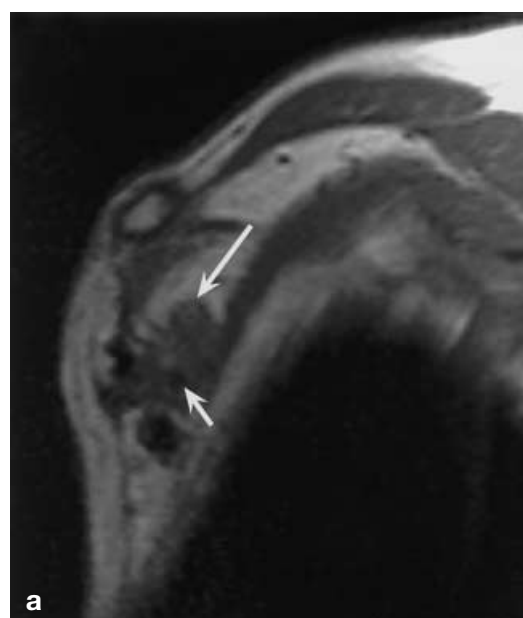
A patient with brachial plexopathy 17 years after a mastectomy. Clinical and MRI follow-up 3 years later showed no change, consistent with radiation fibrosis. a Sagittal T1-weighted image shows diffusely thickened cords (*long arrow*) cranially of the axillary artery (*short arrow*). b Coronal T1-weighted image demonstrates a voluminous brachial plexus (*arrows*) without a focal mass lesion
